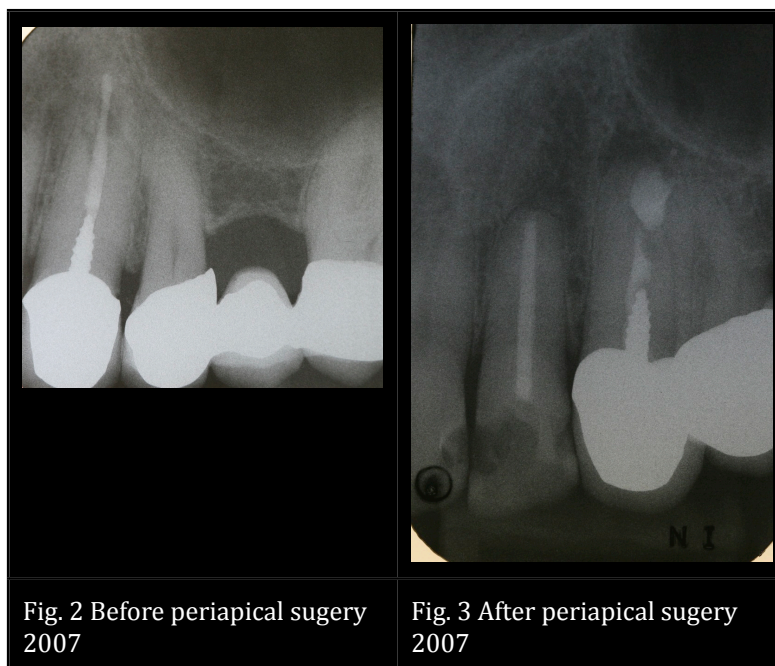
Before periapical surgery 2007
